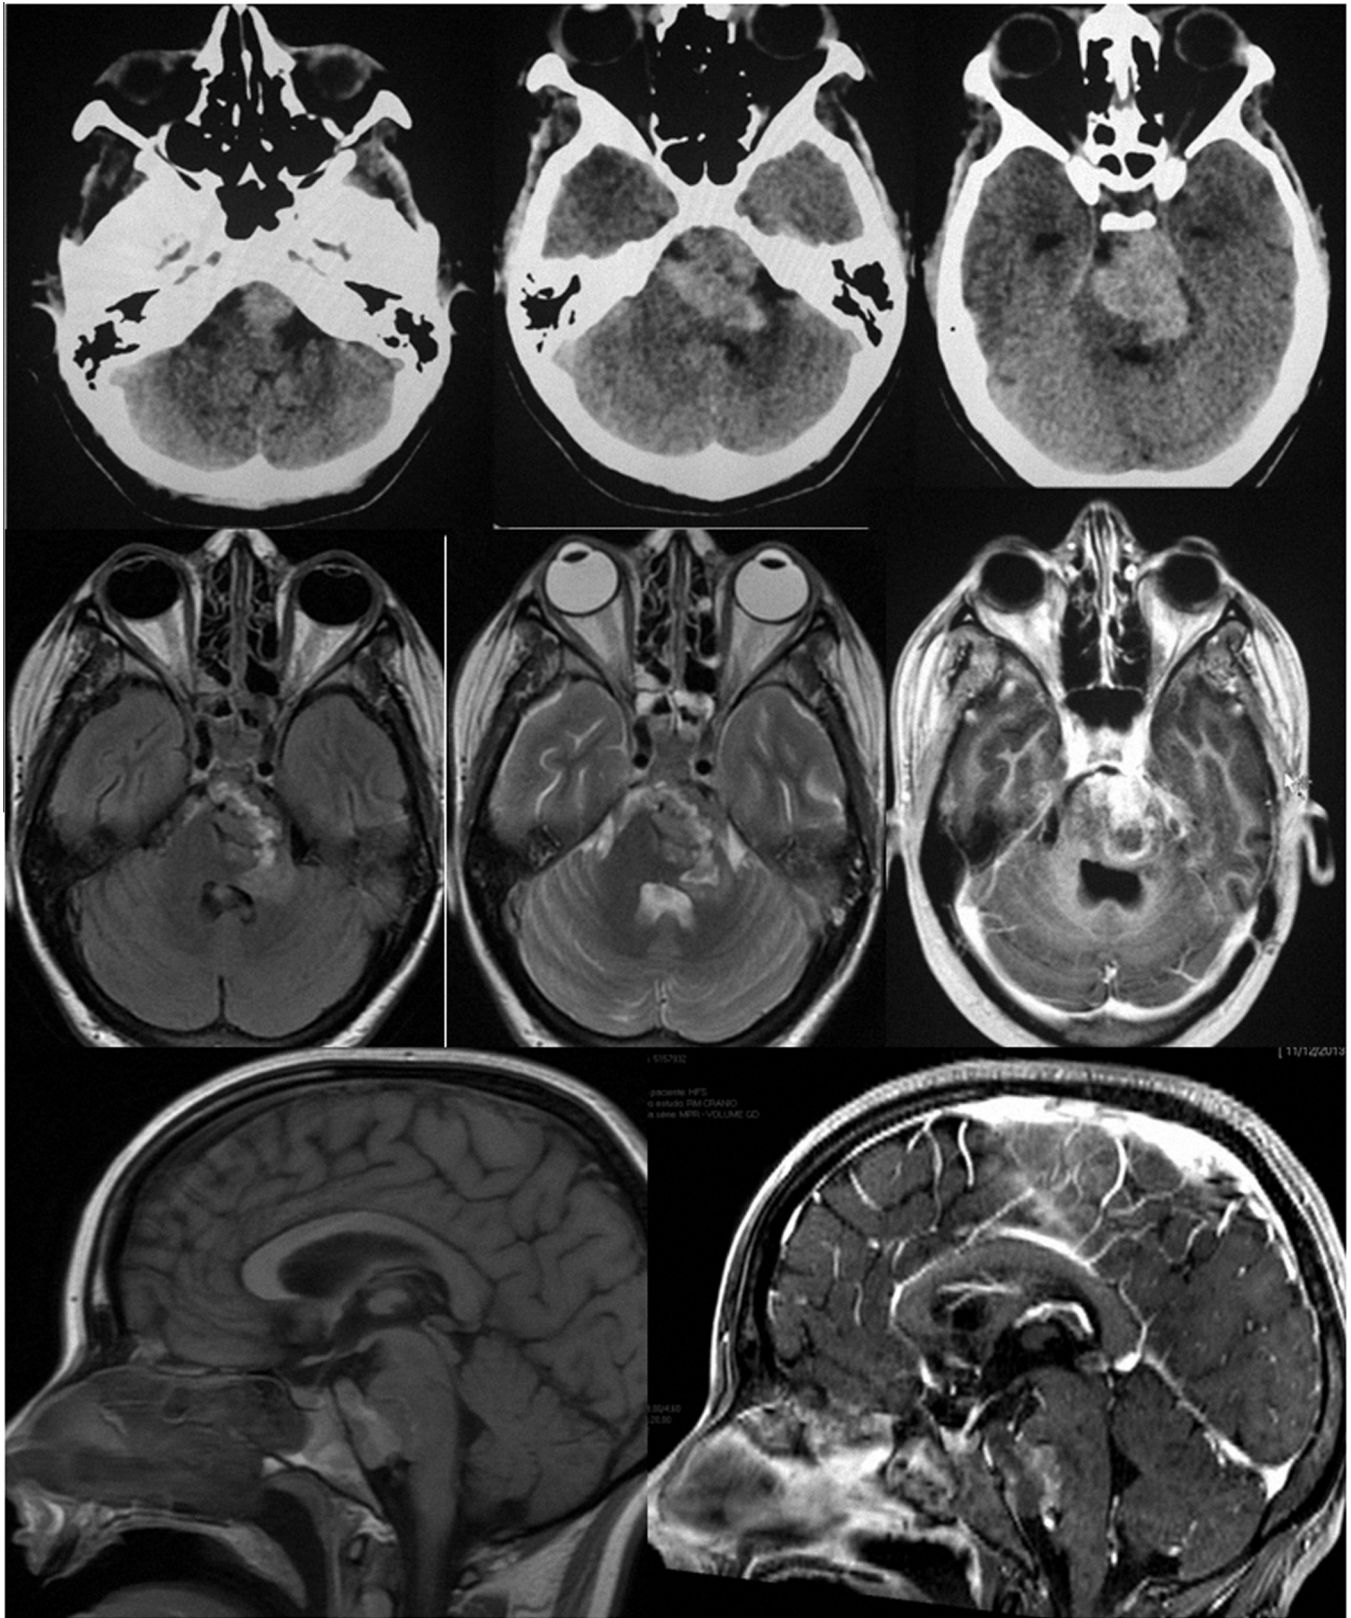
(Top) Axial CT scans at presentation showing a posterior fossa hematoma. (Middle) Axial MRI with fluid attenuated inversion recovery (left), T2-weighted (middle) and T1-weighted with contrast sequences showing the brainstem intradural chordoma. (Bottom) Sagittal T1-weighted MRI with (right) and without (left) contrast showing the brainstem intradural chordoma, arising from the clival synchondrosis, which strongly suggests the diagnosis of chordoma.
